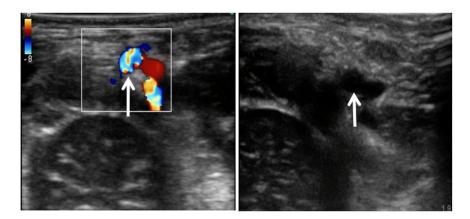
Color Doppler (left) and two-dimensional (right) images of the left axillary artery (arrow) during ultrasound guided access
